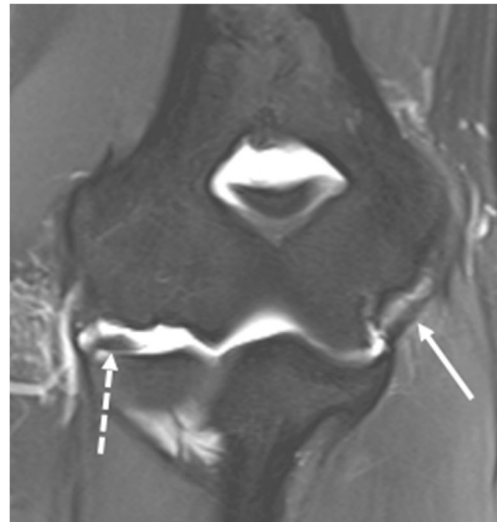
Medial epicondyle apophysitis in a 15-year-old boy, a baseball pitcher with medial elbow pain. a Coronal T1-weighted MR image of the elbow demonstrates avulsion of the inferior aspect of the medial epicondylar apophysis (*solid arrow*), caused by repetitive traction injury from the ulnar collateral ligament (*dashed arrow*), which also
